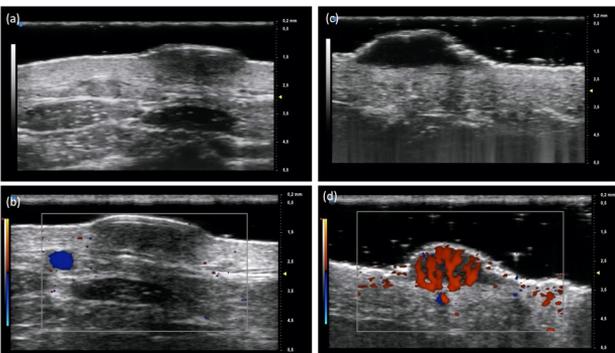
Examples of B-mode and colour Doppler images obtained for a melanocytic naevus (a, b) and a malignant melanoma (c, d), respectively. The melanocytic naevus appears as an oval inhomogeneous non-vascularized hypoechoic lesion (a,b); instead, the melanoma appears as a fusiform vascularized inhomogeneous hypoechoic lesion (c,d).
